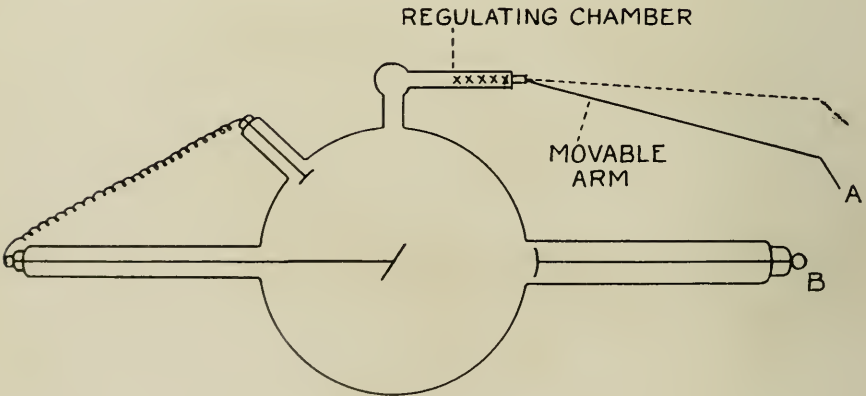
X-ray tube with vacuum regulator.
